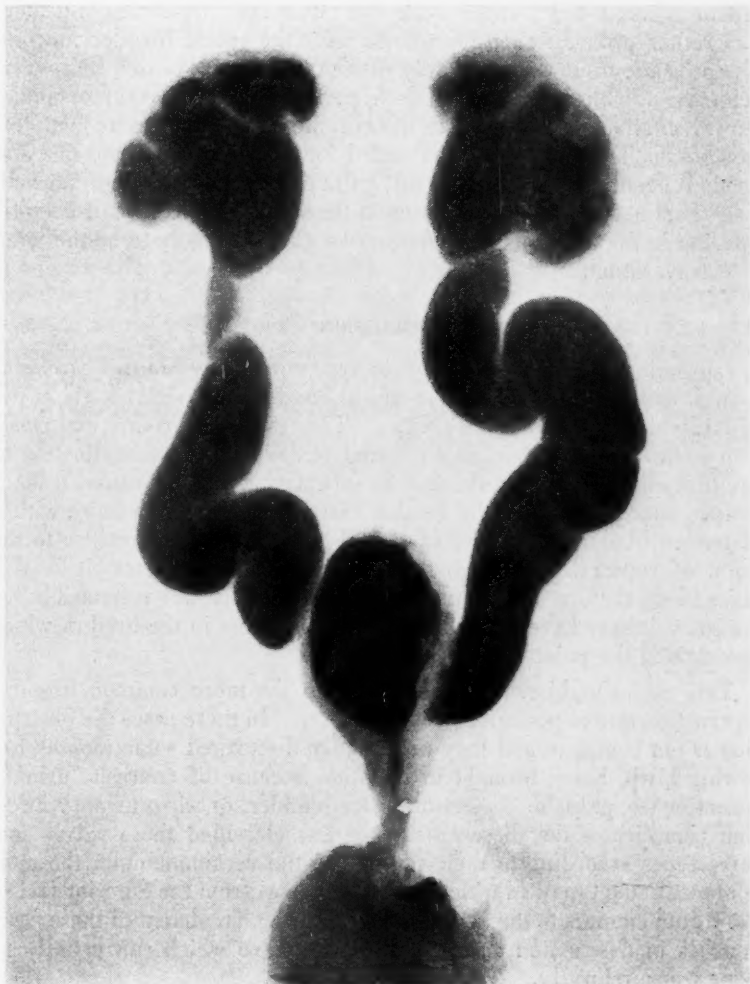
Roentgenographic outline of urinary tract after injection with contrast medium—arrow indicates point of obstruction.
